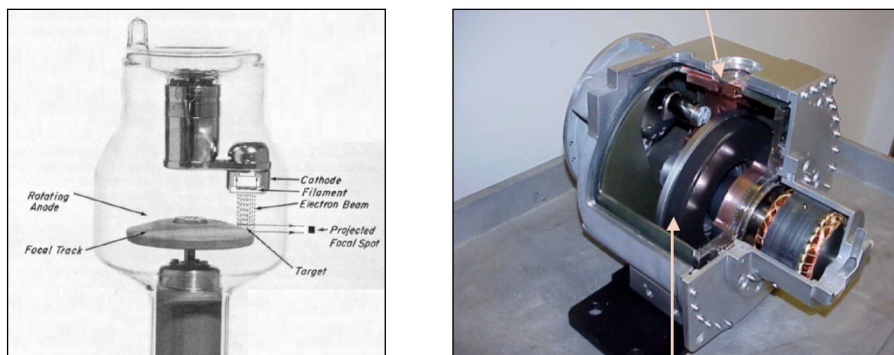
Primitive X-ray tube example (left) and actual X-ray tube (with shielding) (right).
